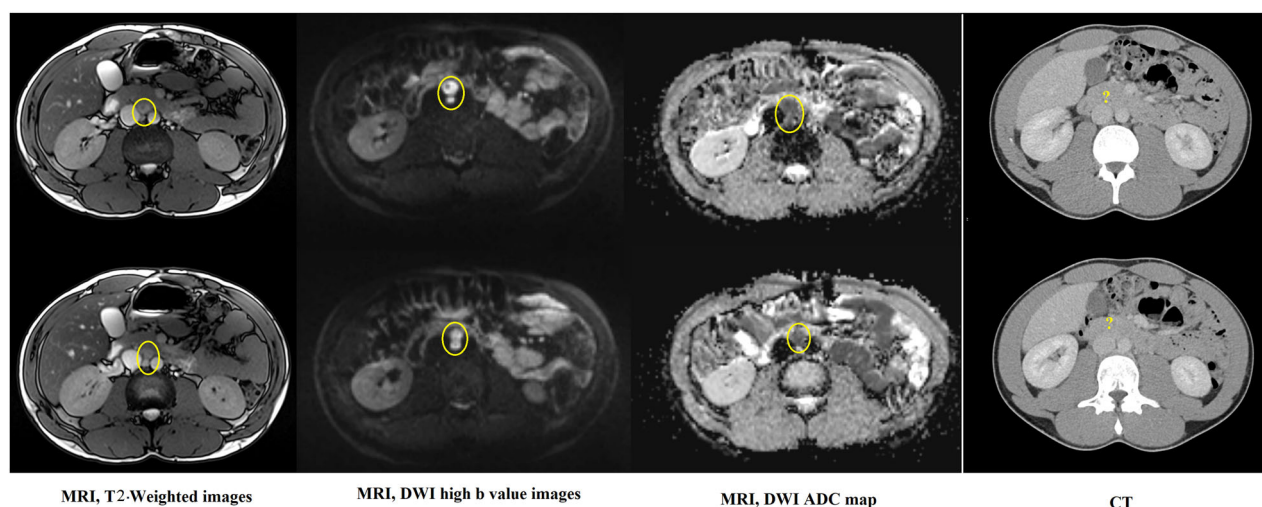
A 29-year-old man treated for a NSGCT pT2 with right radical orchidectomy and chemotherapy. Follow-up imaging 6 months later showed a round retroperitoneal aortocaval LN of 1.5 cm. The LN was not visible on the CT because it was a patient with minimal intra-abdominal fat and the LN had the same density as the adjacent pancreas. The LN was detected on MRI due to the marked restricted diffusion (yellow circles). A laparoscopic lymphadenectomy confirmed LN metastasis of the NSGCT
